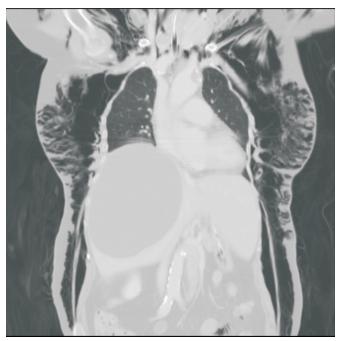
Coronal view of chest CT with lung windows showed the massive subcutaneous emphysema.
